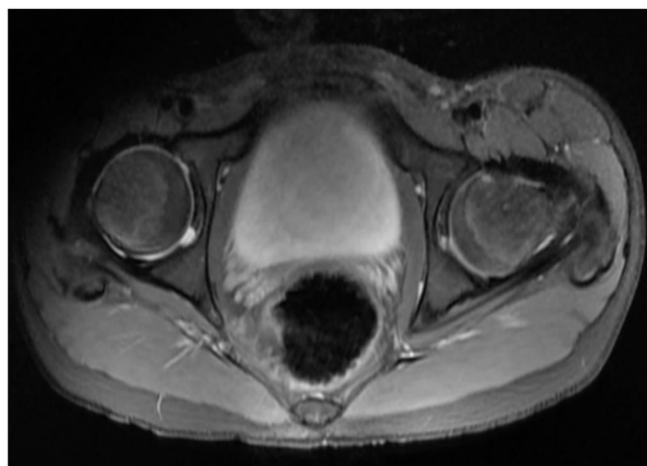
Magnetic resonance imaging at final follow-up (axial).
